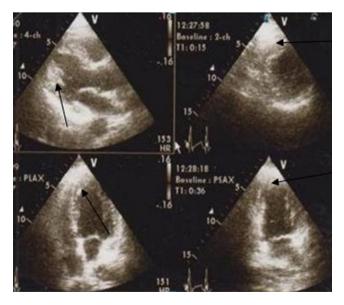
Echocardiography in multiple views shows apical cyst. (1a, left upper image): long axis view shows cyst with black vertical arrow. (2a, right upper image): four chamber view shows cyst with black transverse arrow. (3a, left lower image): four chamber view shows wall of cyst with vertical black arrow. (4a, right lower image): four chamber view shows cyst with transverse black arrow.
